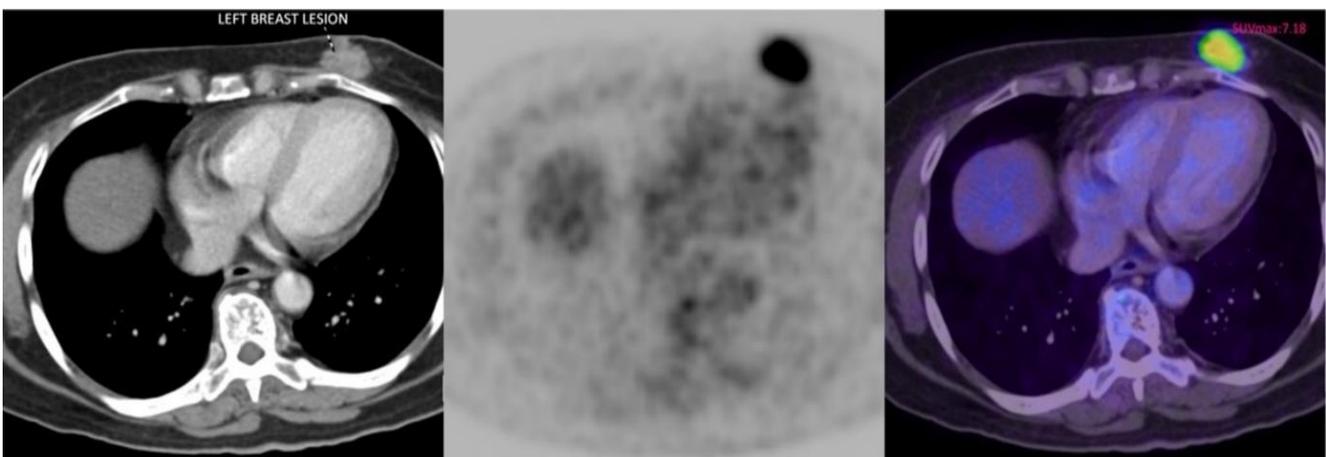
CT(3a), PET(3b), and fusion(3c) images with SUV max uptake of 7.18 in the left breast lesion.
